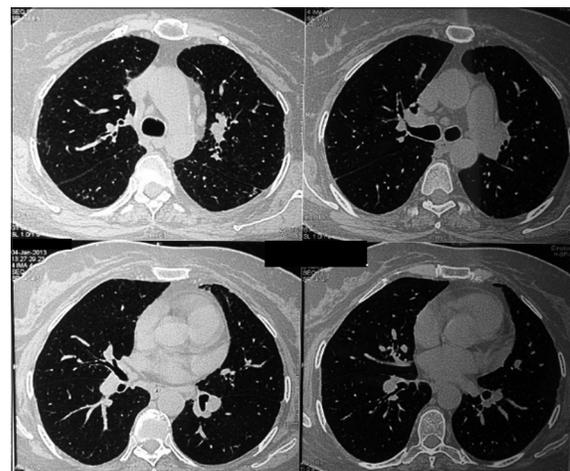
High-resolution computed tomography chest showing remarkable improvement after treatment
